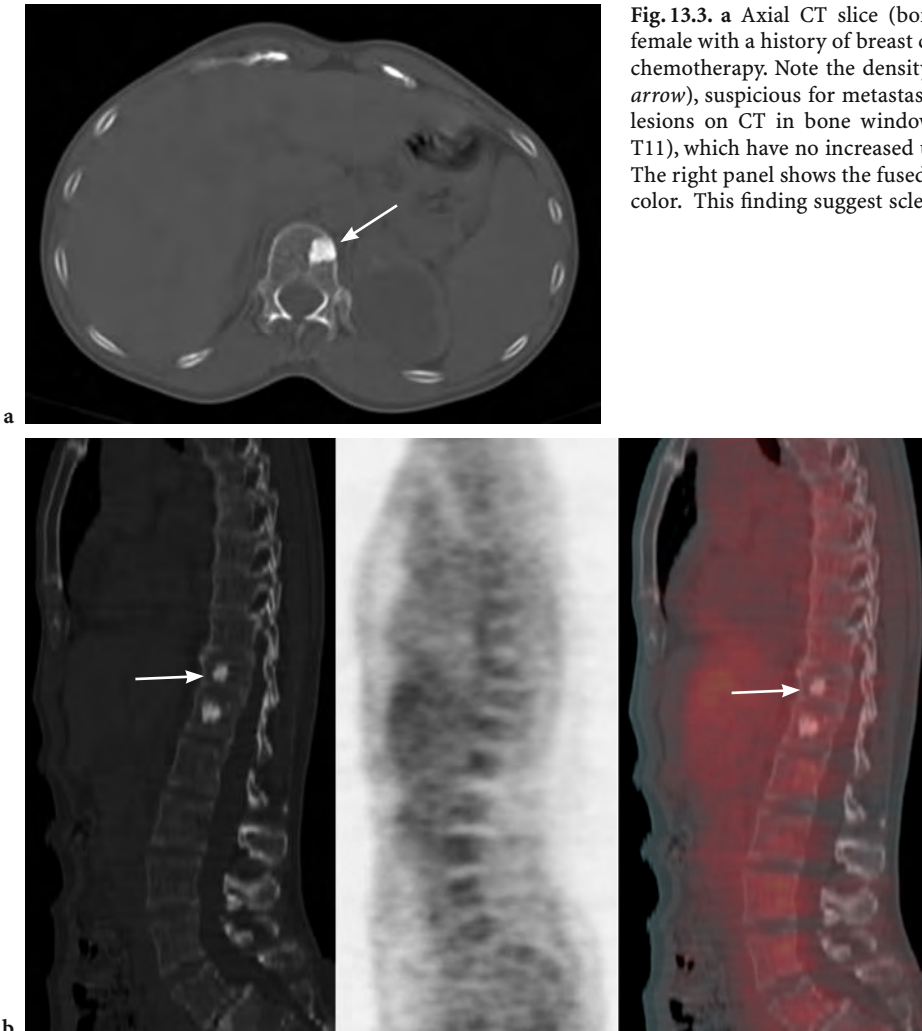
a Axial CT slice (bone window), of a 53-year-old female with a history of breast cancer. Status post surgery and chemotherapy. Note the density in the vertebral body (*white arrow*), suspicious for metastasis. b Sagittal images show two lesions on CT in bone window (*left, white arrow* indicates T11), which have no increased uptake on PET (*middle panel*). The right panel shows the fused image, CT in gray and PET in color. This finding suggest sclerotic bone lesions
